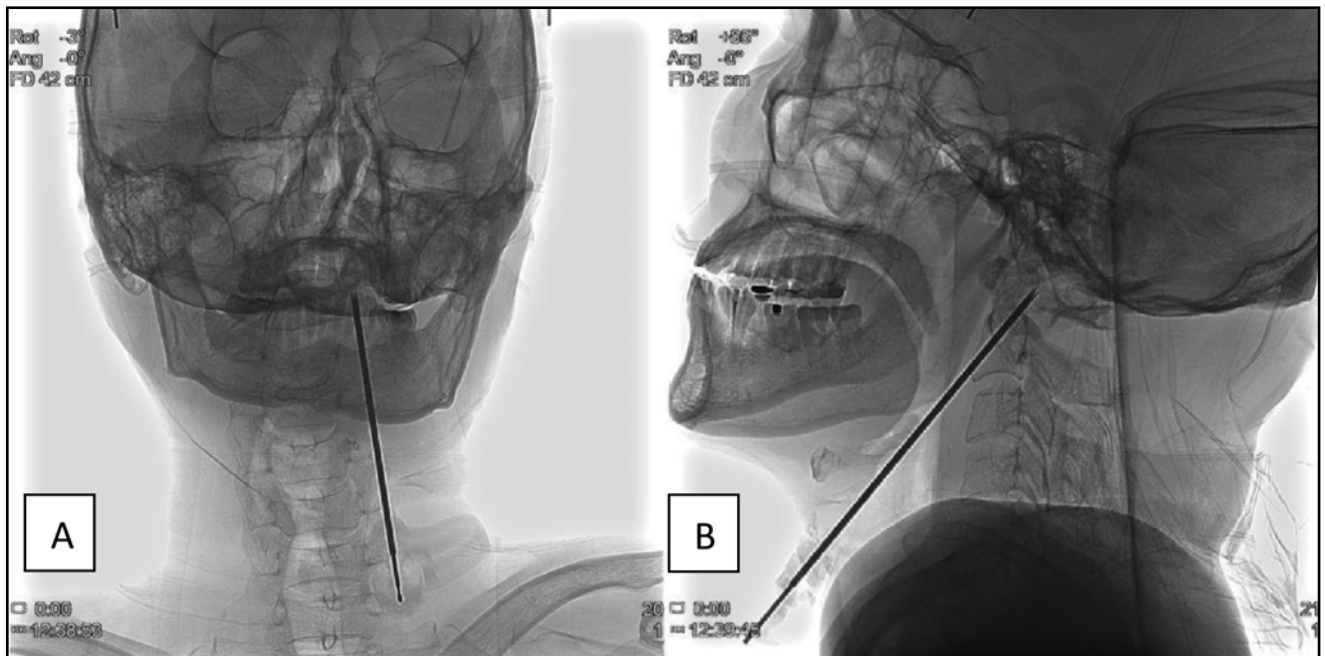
13G puncture needle was inserted into the left lateral mass of the C1 vertebral metastasis body through the body surface puncture point. Images were derived from multiple C-arm CT scan. (A). Front view; (B) Side View.
